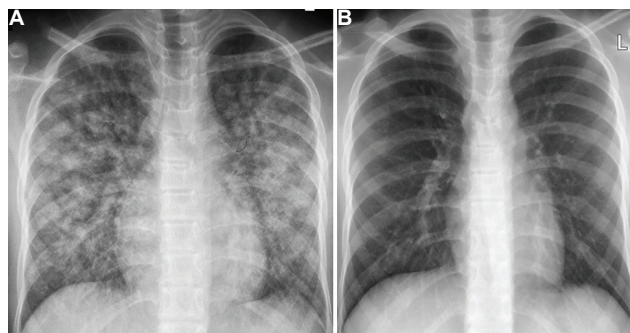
(A) Chest radiograph showing bilateral lung infiltrates consistent with acute respiratory distress syndrome. (B) A normal radiograph at a three-week follow up.
